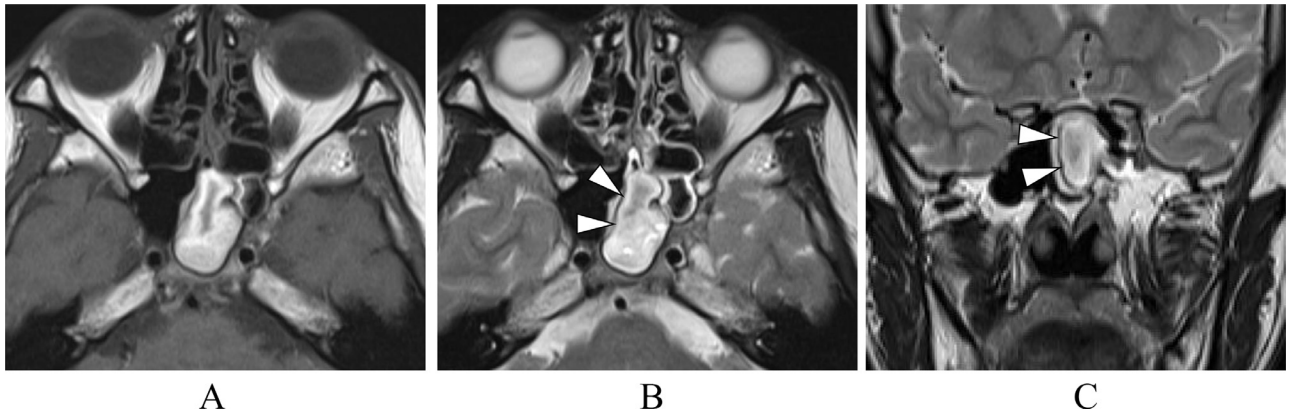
Preoperative nonenhanced MRI findings. (A) T1-weighted axial image, (B) T2-weighted axial image, (C) T2-weighted coronal image. Lesions of the left sphenoid sinus were heterogeneous high-intensity internally in both T1- (A) and T2-weighted images (B and C), and a marked low-intensity rim (arrowhead) was observed inside of high-intensity area which shows sphenoid sinus mucosa (B and C).
